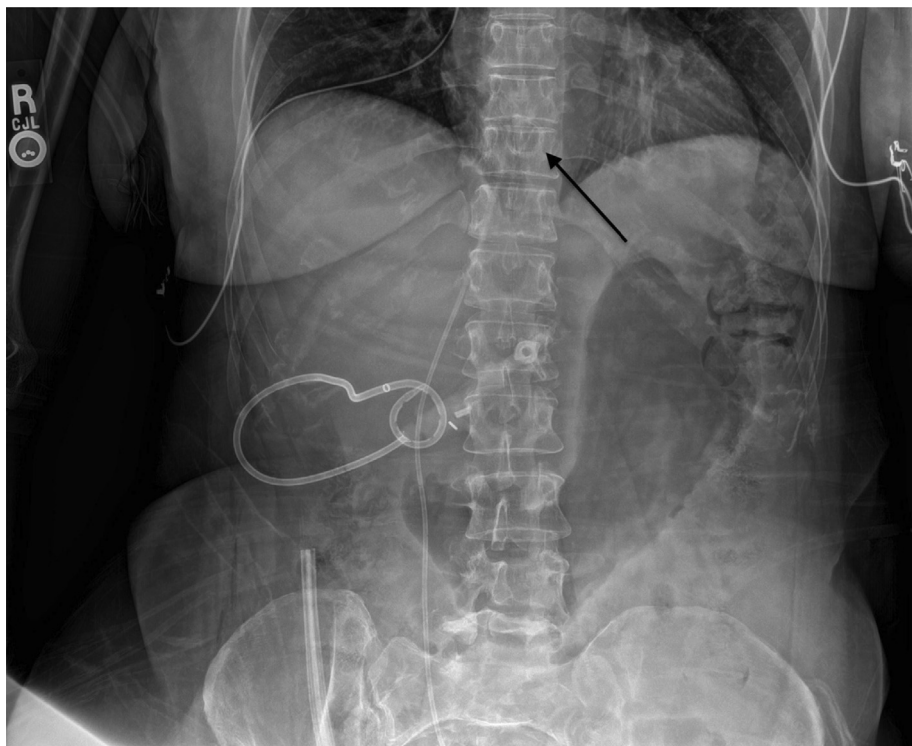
Abdominal X-ray in the immediate postoperative period at the external hospital, showing a medially placed ureteral stent with a proximal end (black arrow) located in the right atrium.
